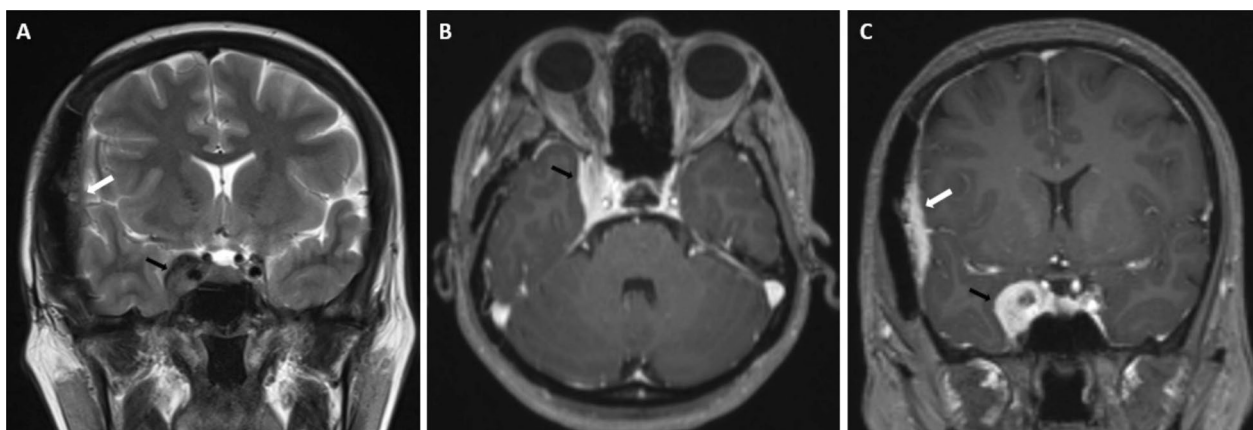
Postoperative T2-weighted coronal (A), postcontrast axial (B) and coronal (C) images show a residual-relapse area of the lesion in the right frontotemporal region (white arrow). The expansion and enhancement of the right cavernous sinus appears to progress (black arrow)
